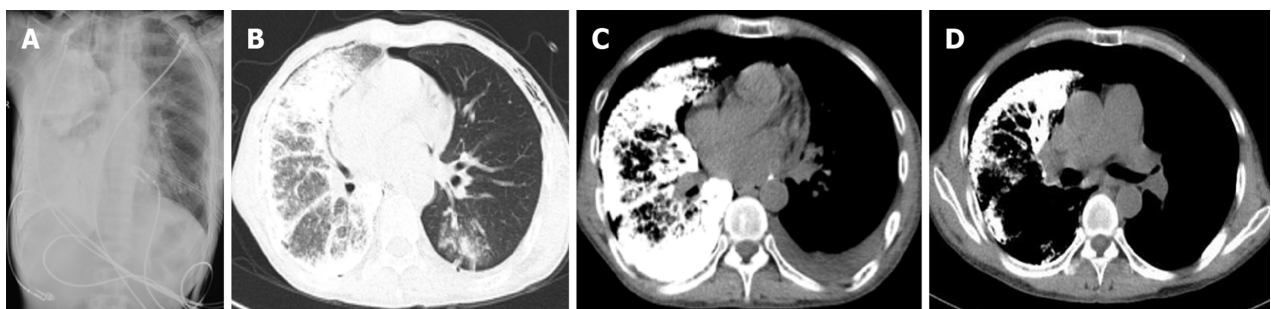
Postoperative imaging. A: Postoperative chest radiograph (1 wk after surgery) revealing slight exudation in the left lung; B: High-resolution computed tomography (CT) image showing good dilation of the left transplanted lung, with mild pulmonary perfusion injury and local infection; C: CT image showing left-sided pleural effusion; D: CT image showing a left-sided main bronchial stricture.
